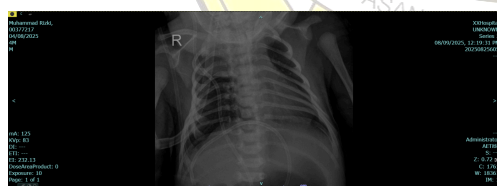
Chest X-ray, AP projection, supine position (August 9, 2025)
